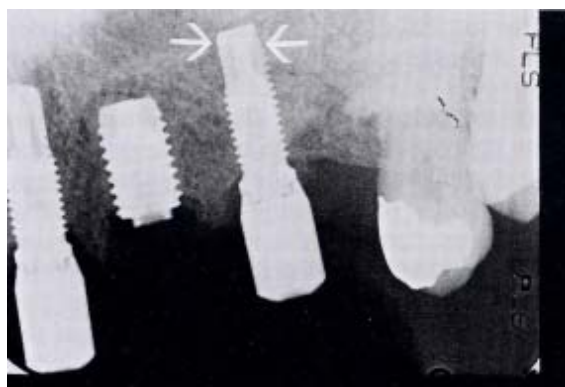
Radiograph of the implants and the grafted sinus 9 months post-operative. Note normal trabecular bone covering whole length of the implant in the grafted sinus ( $\leftarrow$ ). Also, note osseointegration of all the inserted implants.
